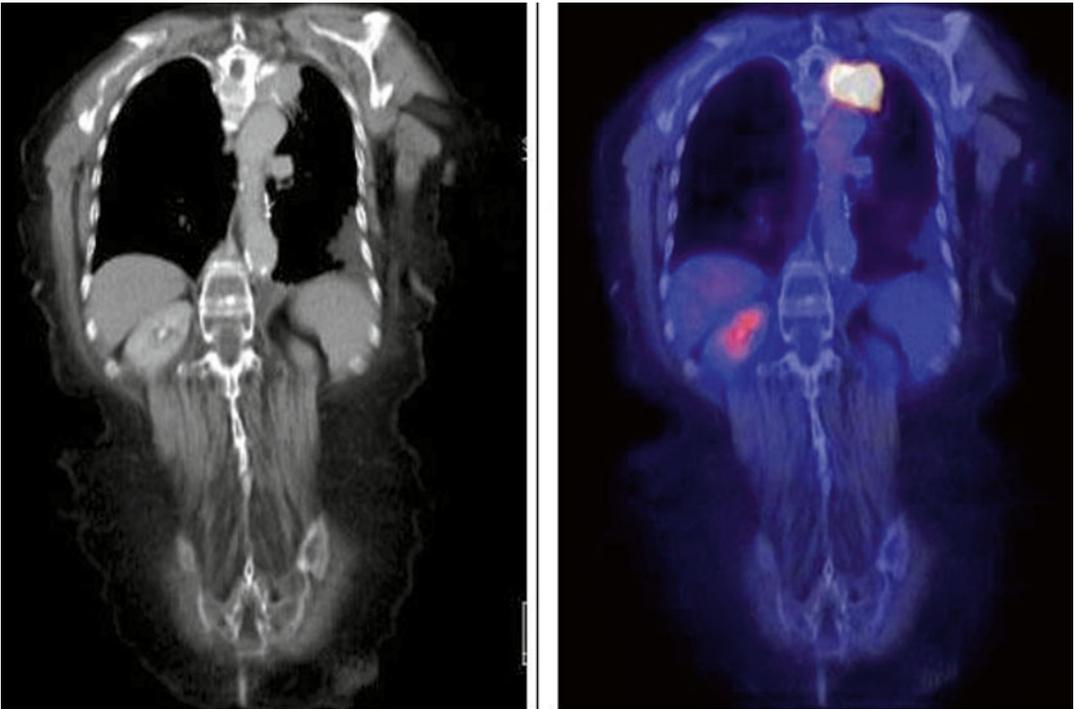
Initial PET/CT, coronal view
